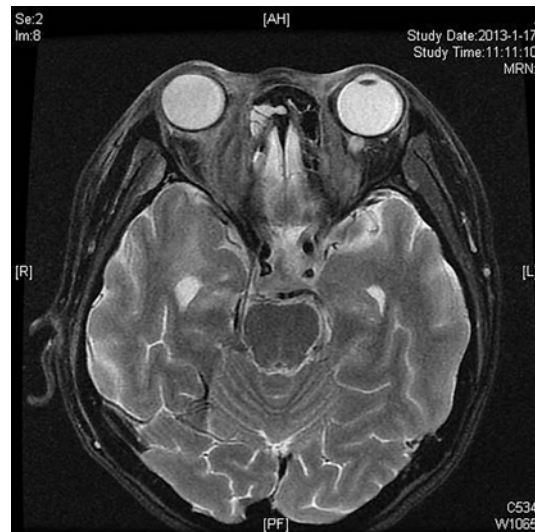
Orbital magnetic resonance images showing widespread necrosis infiltrated into right sinus cavity, orbit, and even zygoma.
